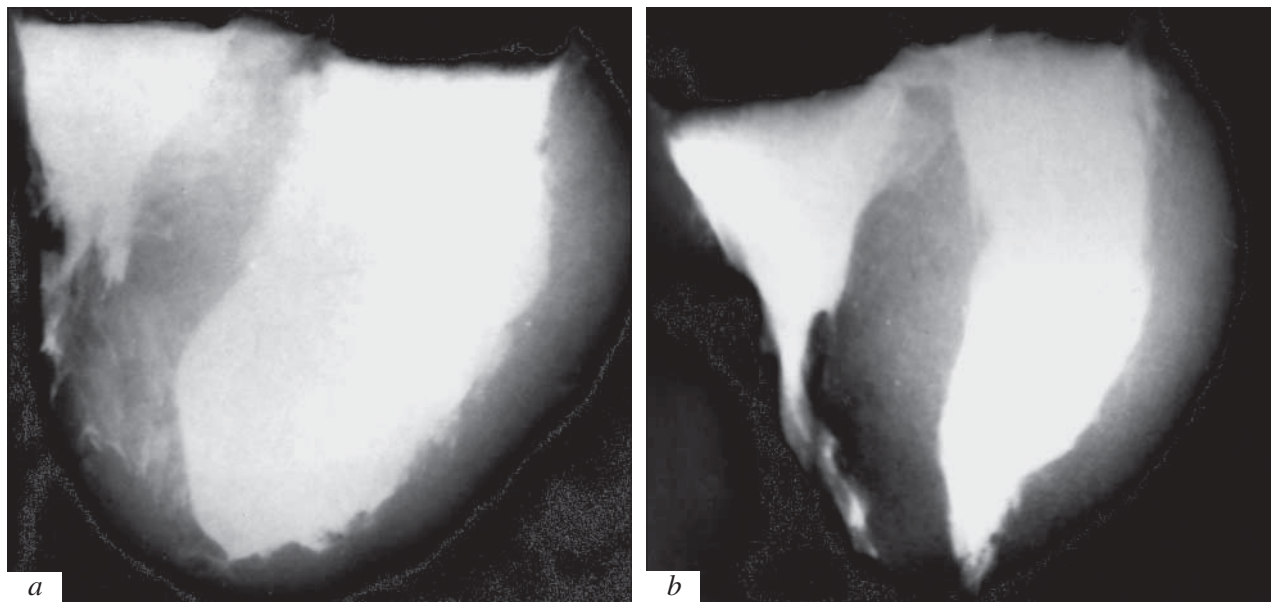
Reduced-volume reconstruction of the right ventricle during postinfarction remodeling of the heart. Postmortem contrast cardioventriculography. X-ray films, 3-fold demagnification. Fivefold decrease in the size of the cavity and volume of the right ventricle (compared to the left ventricle), which gains a triangular shape during dilatational remodeling (patient G., 54 years, *a*). Sharply hypertrophic interventricular septum displays a free cavity of the right ventricle with a 2-fold reduced volume (compared to the left ventricle) during hypertrophic remodeling (patient V., 56 years, *b*).
